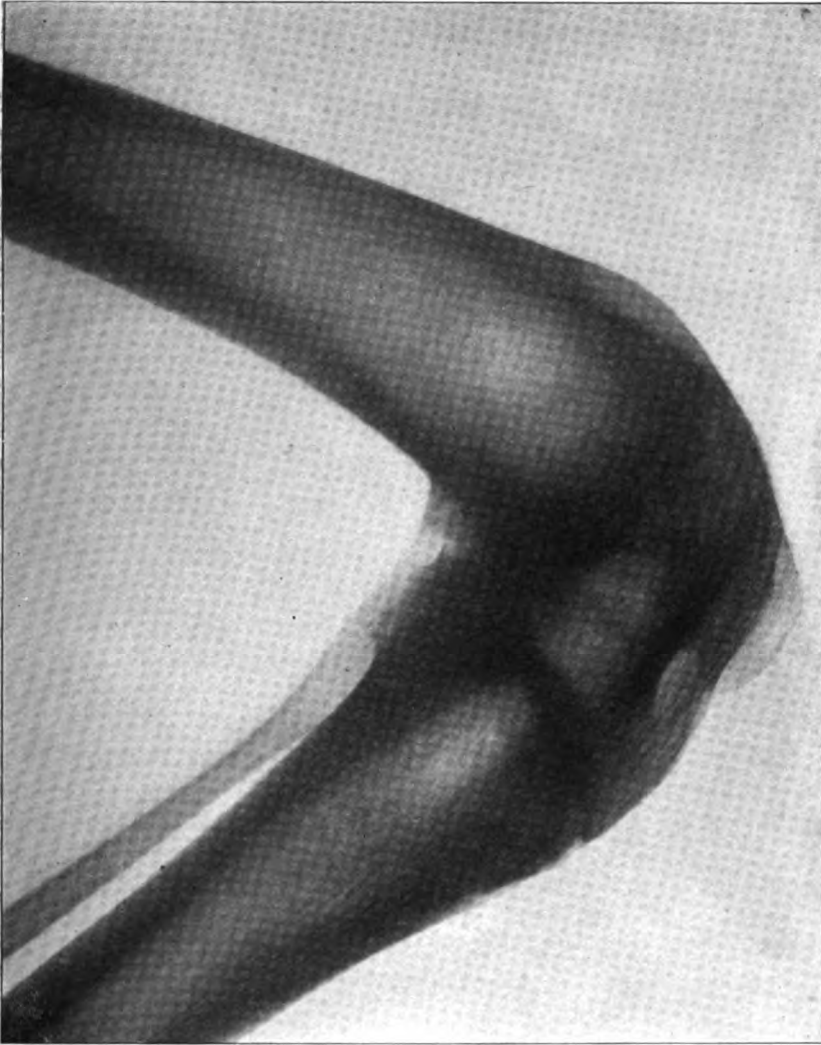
Radiograph of knee shown in Fig. 9.
